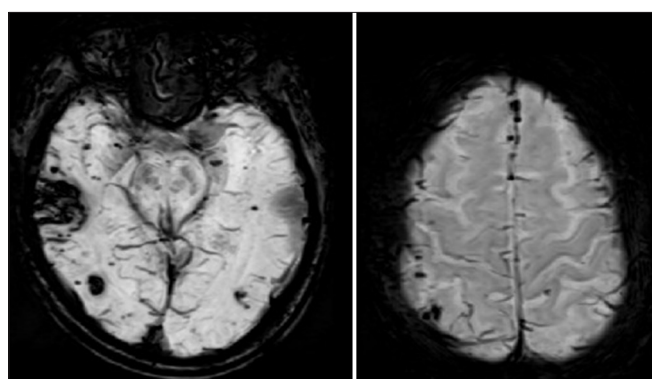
Susceptibility-weighted imaging magnetic resonance imaging from September 2024 demonstrating multiple microhemorrhages in the temporal and occipital lobes.
